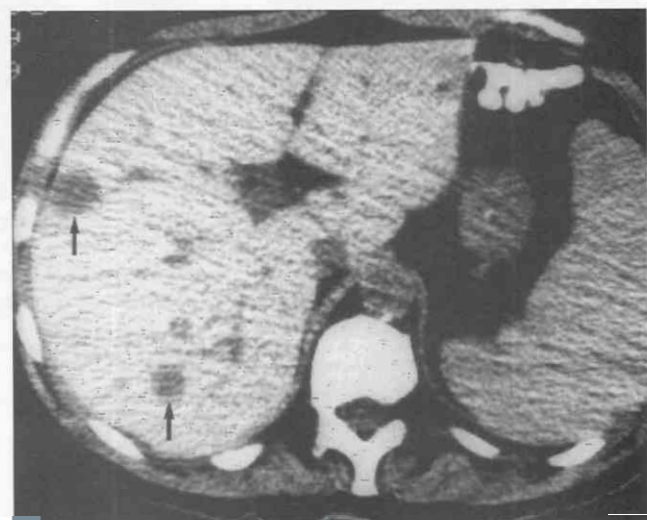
Disseminated candidiasis. CT shows multiple filling defects in the liver caused by fungal abscesses (arrows). (From Kuhlman JE: CT of the immunocompromised and acutely ill patient. In Zerhouni EA [ed]: CT and MRI of the Thorax. New York, Churchill Livingstone, 1990.)
